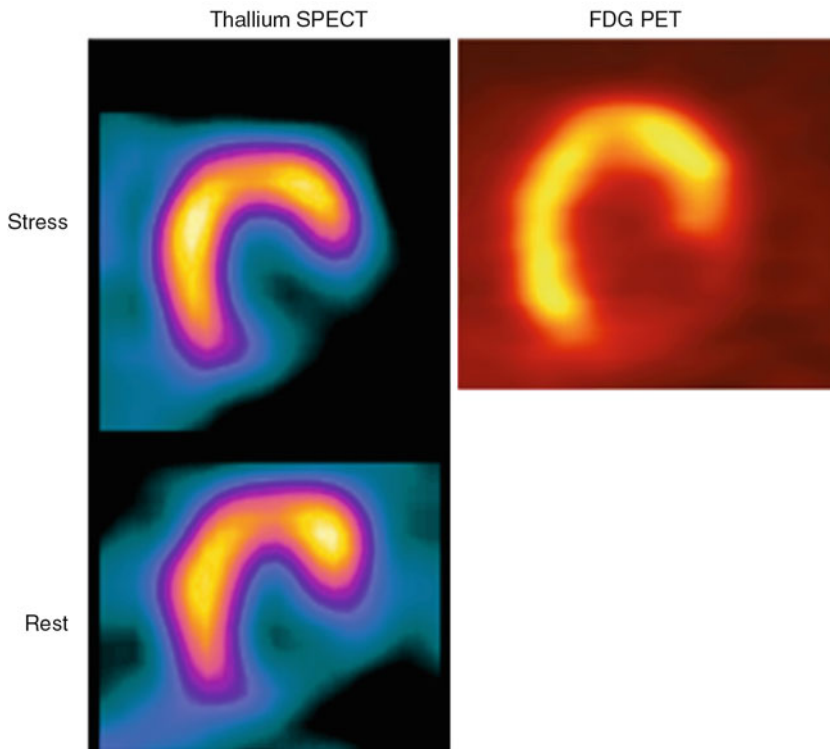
Thallium-201 and ^{18}F -FDG PET images of scarred myocardium. Severe perfusion defect was noted in inferior and inferolateral wall on short axis of thallium SPECT. FDG PET showed matched defect, suggestive of scarred myocardium
